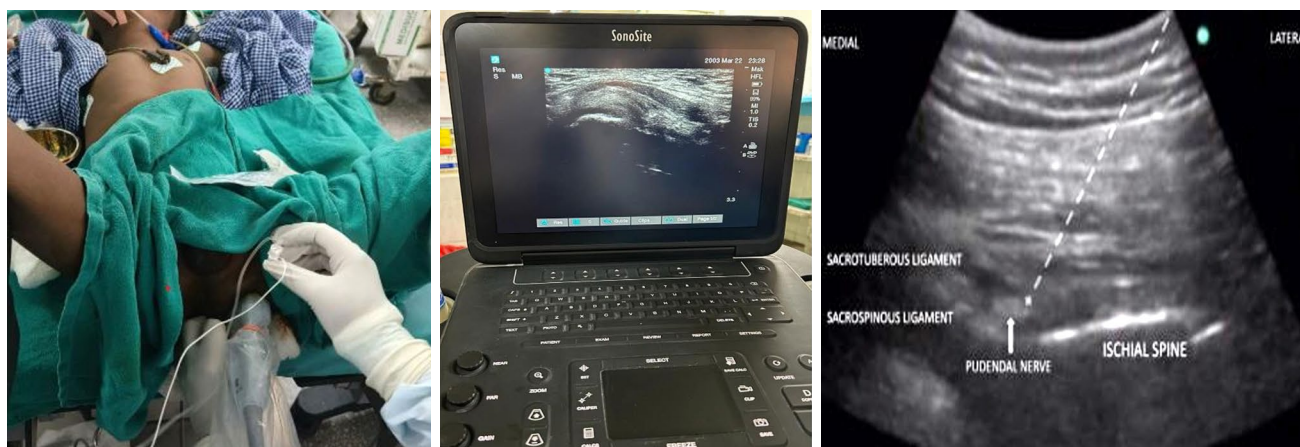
Ultrasound-guided pudendal nerve block image.
